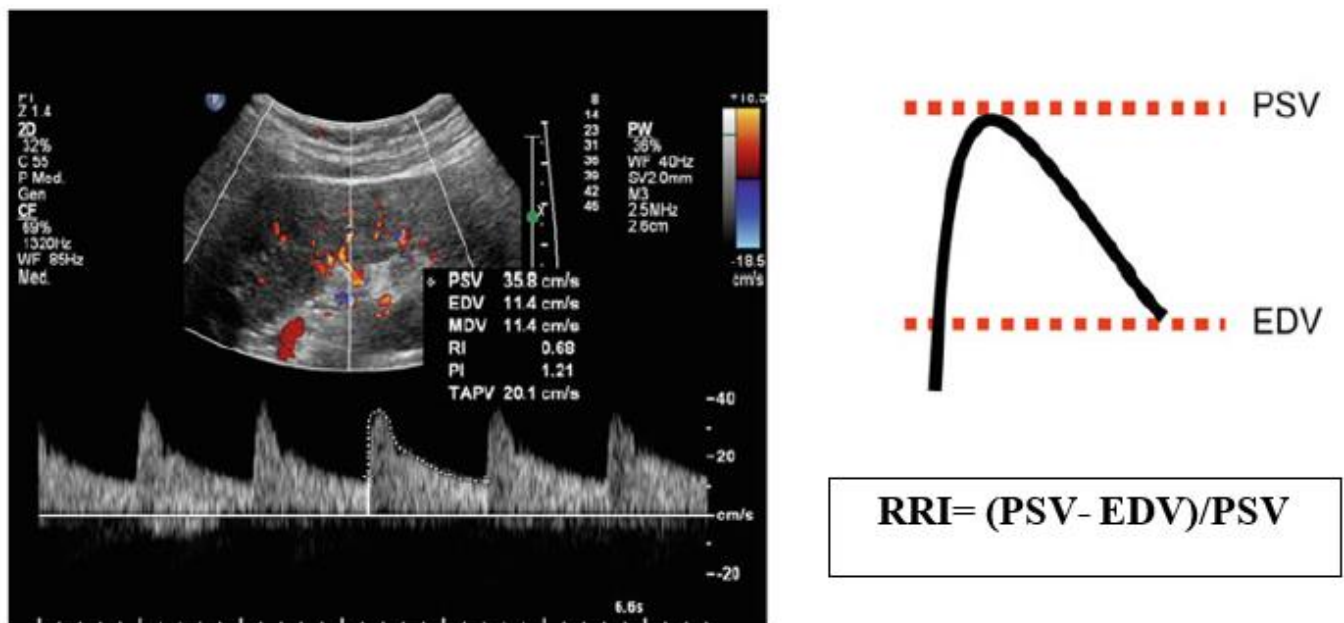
RRI is measured by Doppler sonography in an intrarenal artery, as the difference between the peak systolic (PS) and end-diastolic (ED) blood velocities divided by the peak systolic velocity (PSV)
